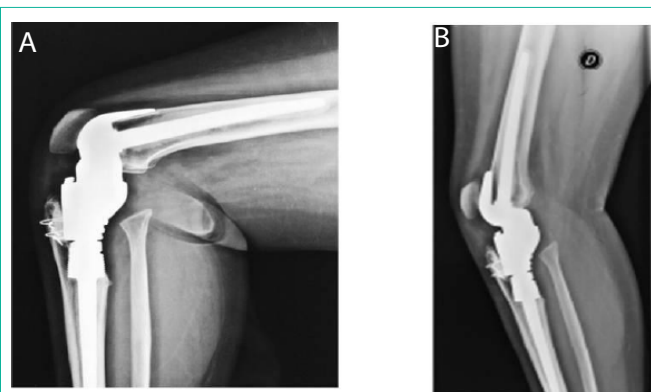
Lateral x-rays of the knee 6 months after surgery. (A) 90 degrees of flexion. (B) 30 degrees of flexion.
